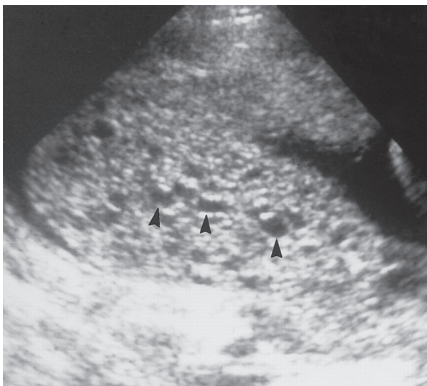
Molar pregnancy. Ultrasound image demonstrates an echogenic mass in the uterine cavity with multiple small, hyperechoic areas (arrowheads).
